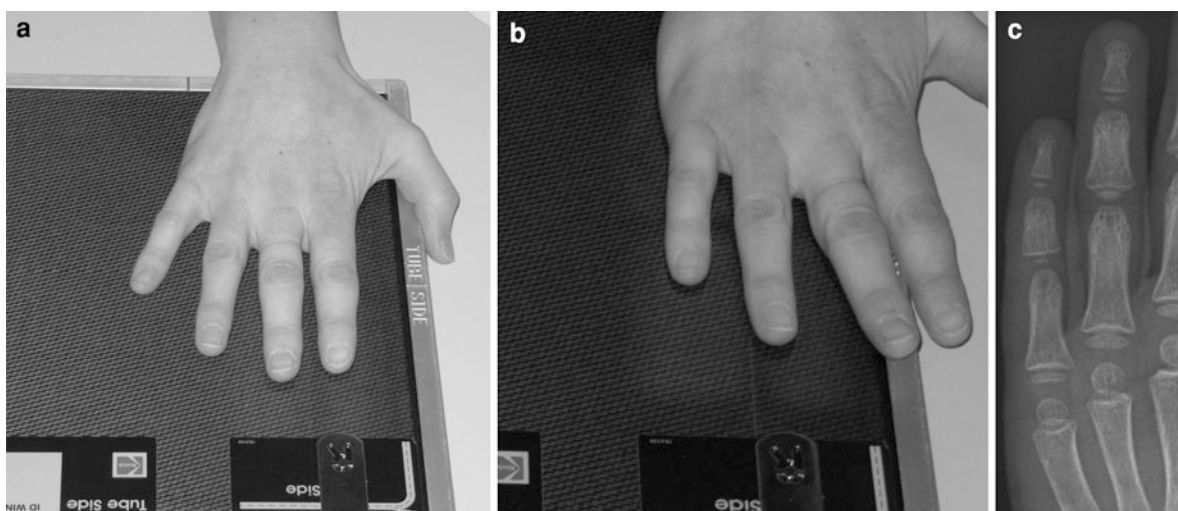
a Patient positioning for PA second and third fingers. b Patient positioning for PA fourth and fifth fingers. c Radiograph of PA fingers
